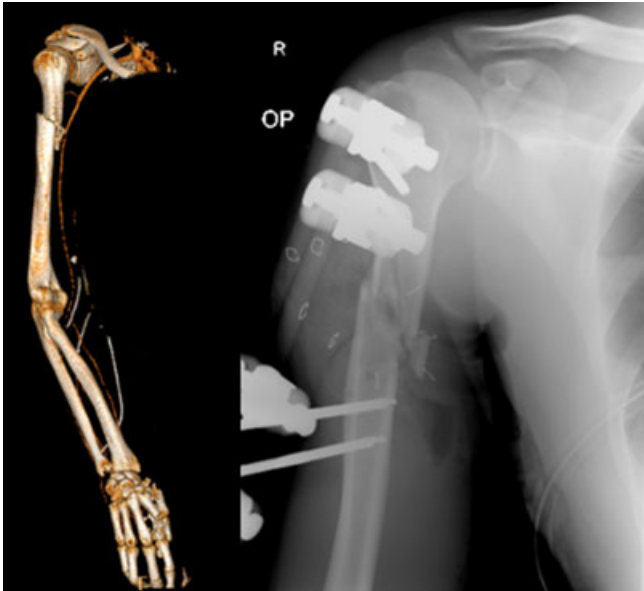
Burst fracture of the right humeral bone. Plain radiography in a.p.-direction after external fixation (right), 3D postprocessing of the fracture and the intact brachial artery (left).
